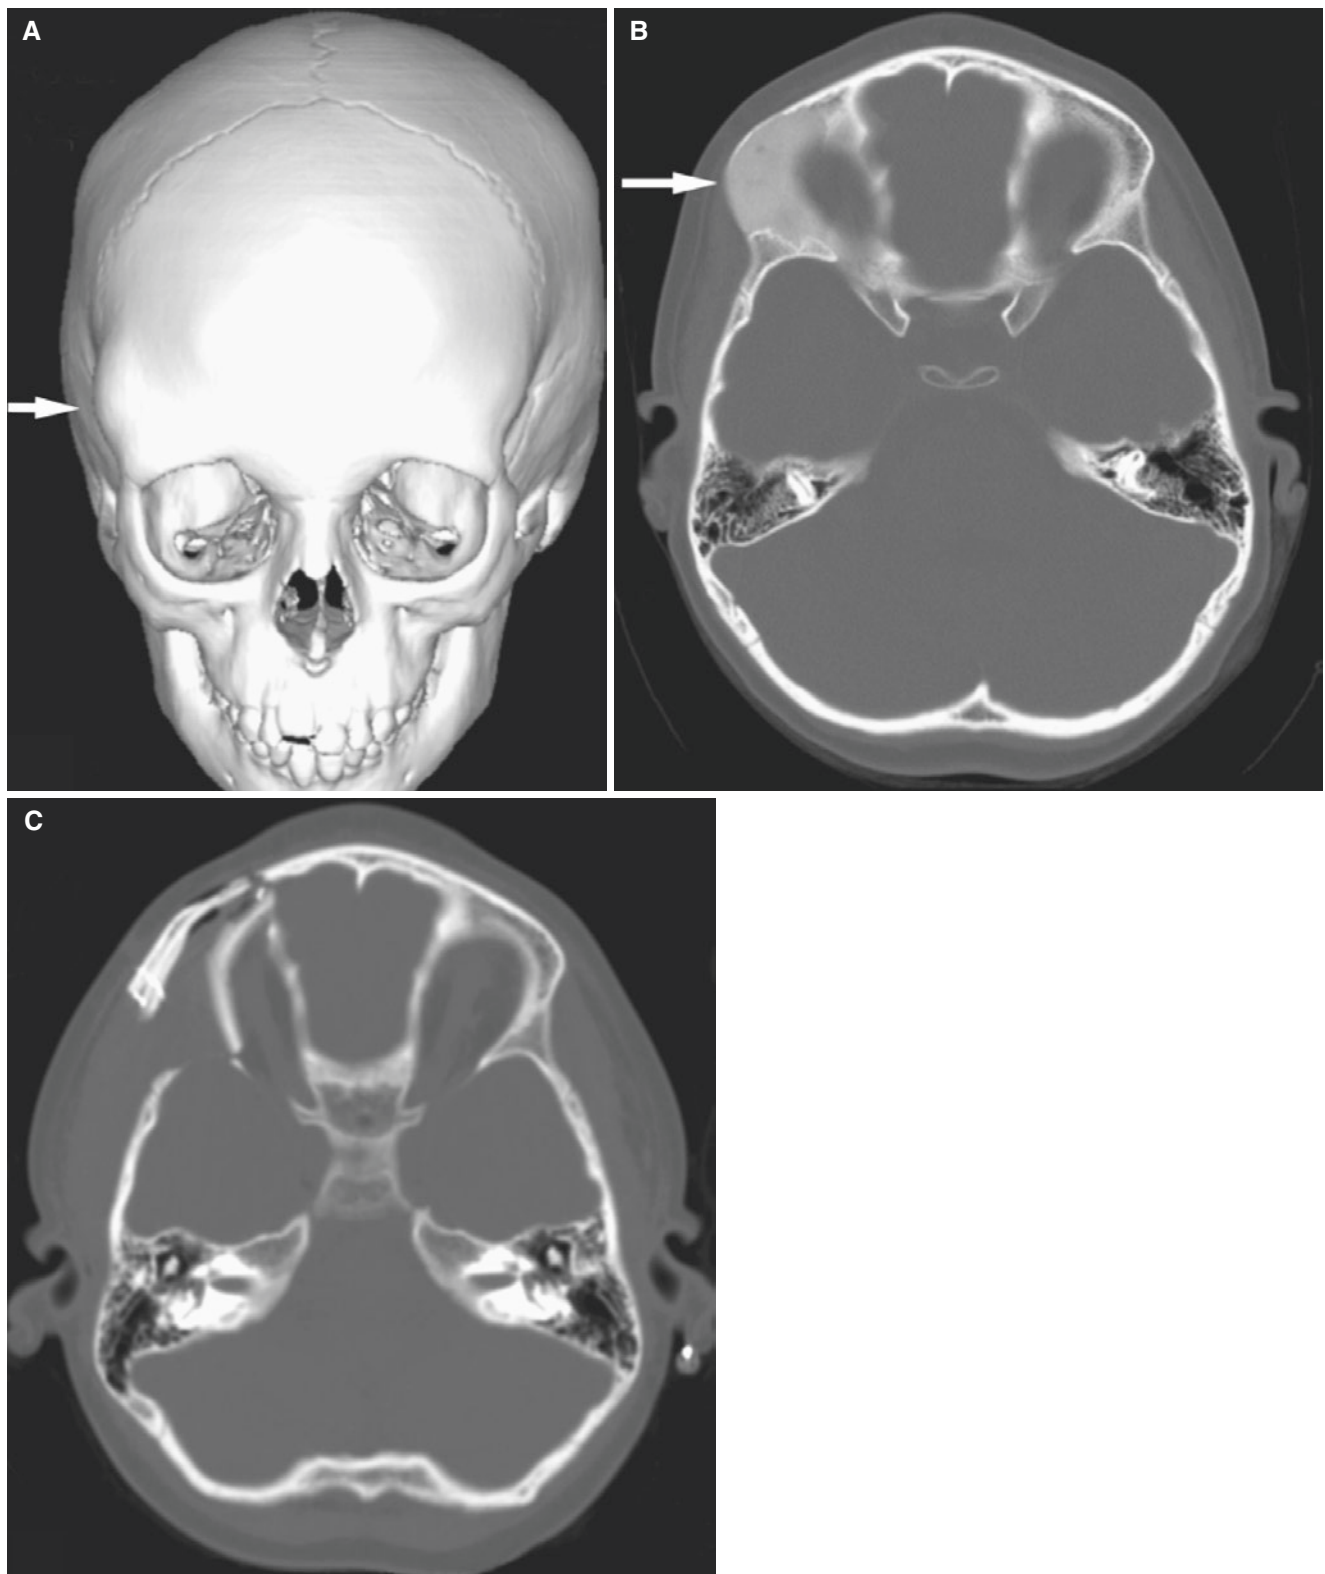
Frontal fibrous dysplasia; 6-year-old female with painless swelling of the right frontal bone. (A) 3D CT image, en face, shows well-defined and smooth swelling (*arrow*). (B) Axial CT image shows
